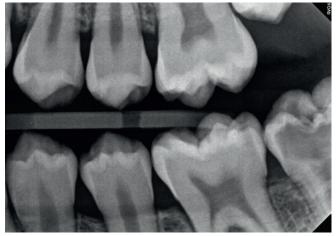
Referral bitewing radiograph showing an intracoronal radiolucency on LL7.
